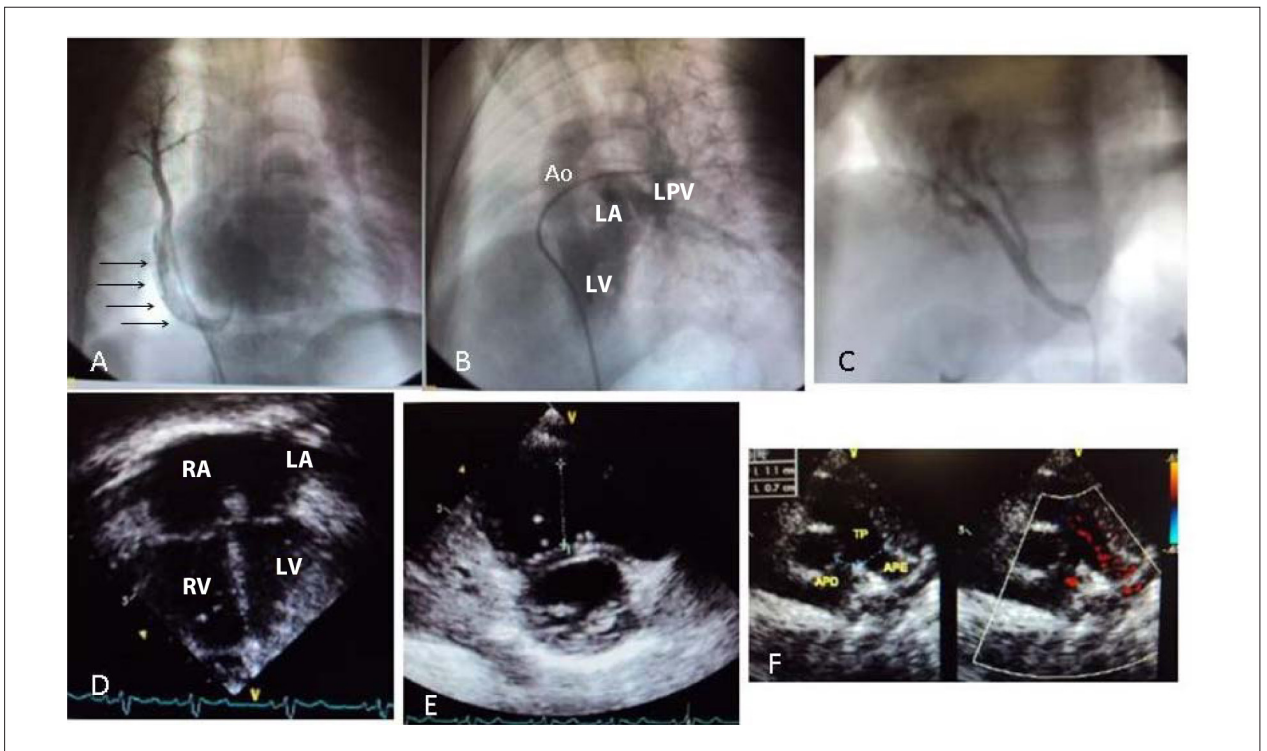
Angiography in right upper pulmonary vein enhances the Scimitar shape of right common pulmonary vein (arrows) towards lower vena cava in A, Left Pulmonary Vein (LPV) in the Left Atrium (LA) in continuity of the Left Ventricle (LV) and Aorta (Ao) in B and systemic-to-pulmonary vessel of descending aorta to right lower lobe in C. Echocardiographic images show the increased right cavities in apical view of 4 chambers in D, the large increase of right ventricle in cross-sectional view in E and dilated pulmonary trunk and left pulmonary artery in cross-sectional view in F.
